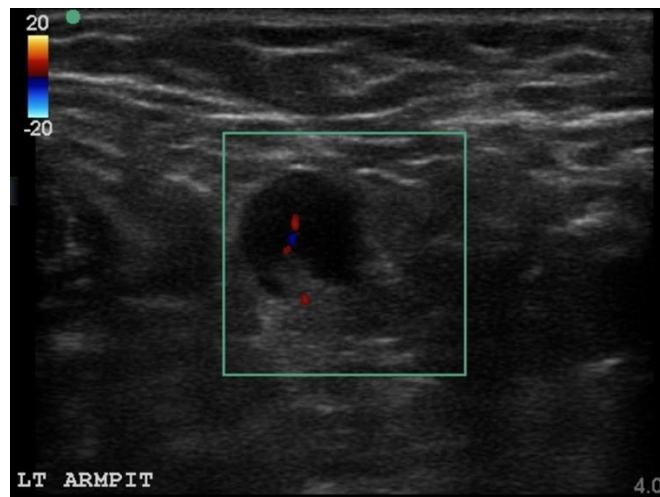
Case 2. Color Doppler ultrasound assessment of the left axillary region revealing positive color Doppler findings of the swollen lymph node.
